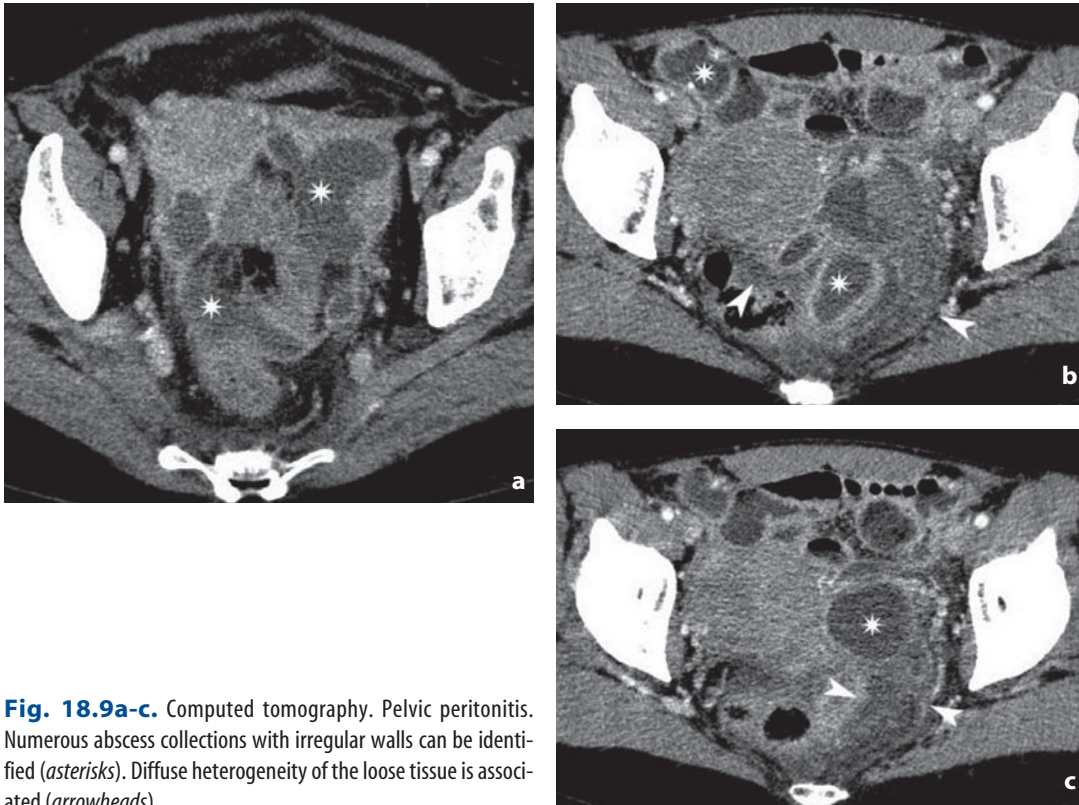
Computed tomography. Pelvic peritonitis. Numerous abscess collections with irregular walls can be identified (*asterisks*). Diffuse heterogeneity of the loose tissue is associated (*arrowheads*)
